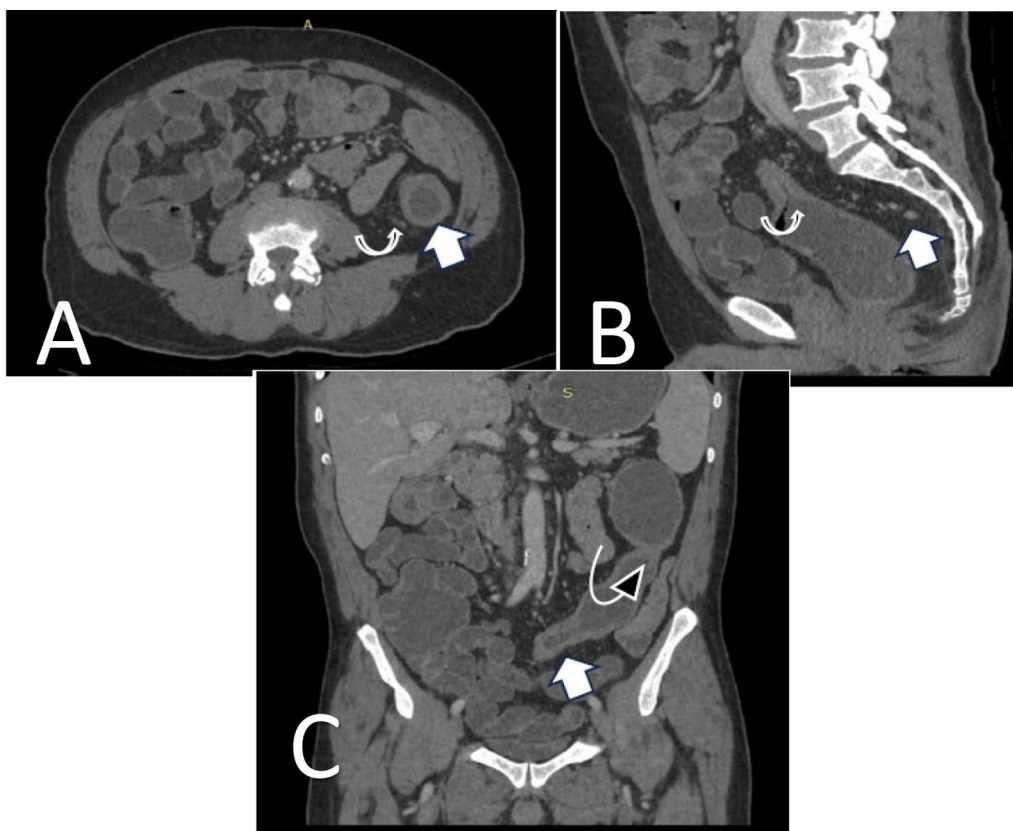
CT enterocolonography with IV contrast (A) axial image shows uniform circumferential mural thickening of descending colon with stratification of its wall (arrow) and mesenteric hyperemia (curved arrow) (B) Sagittal reformatted image shows lymph node enlargement and perirectal stranding (arrow) and rectosigmoid luminal narrowing (curved arrow) and (C) Coronal image shows two areas of luminal narrowing, rectosigmoid one (arrow) and another one in descending colon (curved arrow). *CTE score: 13. Modified Mayo score: 9*
